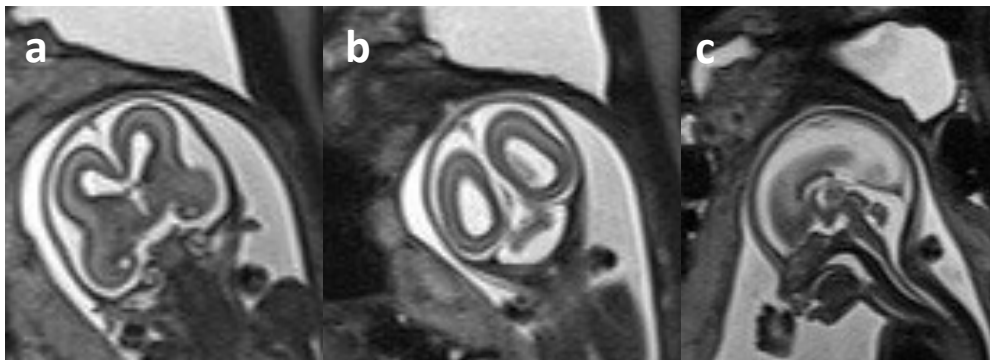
MRI findings at 20+2 GW: a,b,c hypoplastic and dysplastic CC, smaller CSP, dysmorphism of frontal horns and widening of interhemispheric space.
